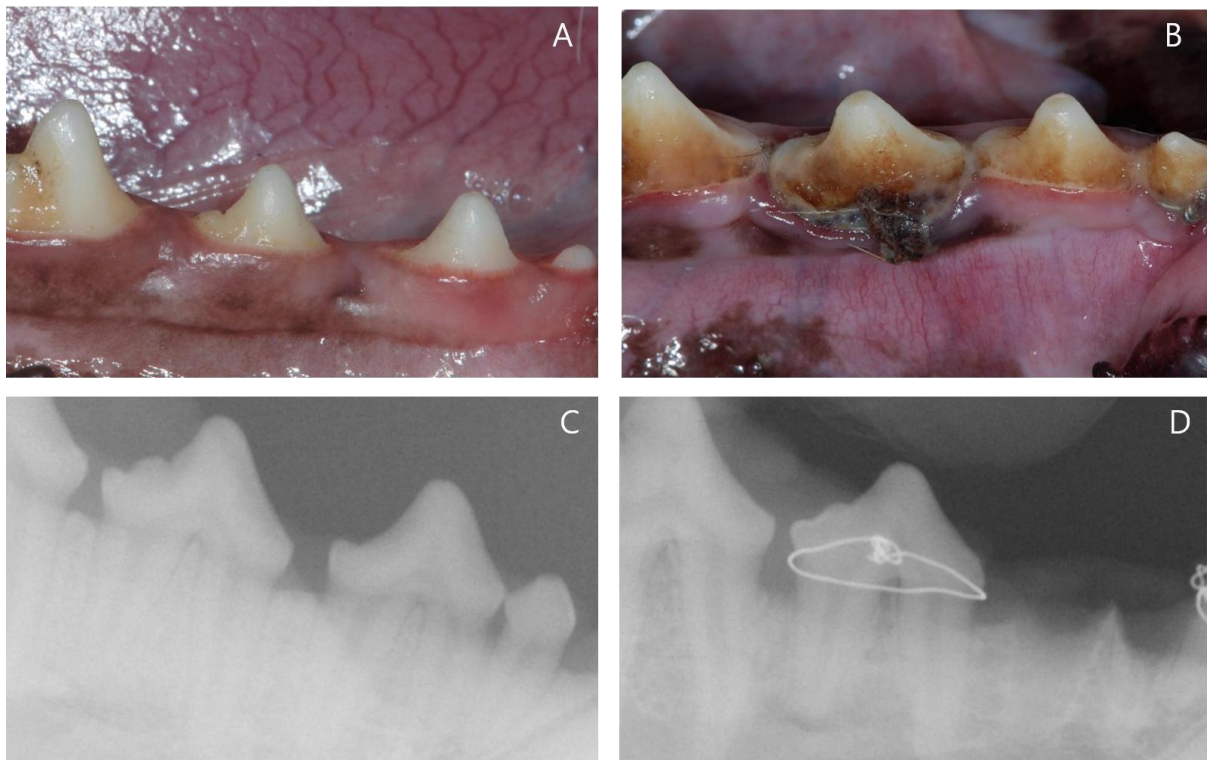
Clinical photos and radiographs taken before and after induction of experimental periodontitis. Healthy periodontal tissue (A) became inflamed (B) due to subgingivally-placed wires wound with ligature soaked in *Porphyromonas gingivalis*. Periapical radiographs of the site confirmed the presence of healthy periodontal tissue (C) and experimental periodontitis (D).
